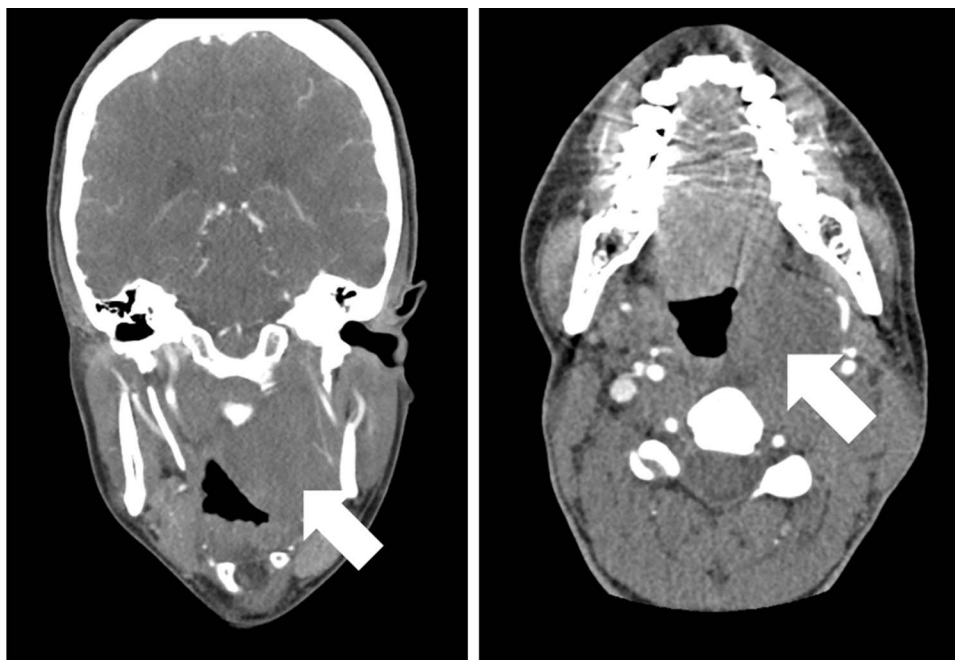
Contrast-enhanced CT angiography showed lateralization of the carotid artery and indentation of the internal jugular vein but ruled out infiltrative tumor growth and bone erosion. Left: coronar view. Right: axial view. The arrows point to the tumor.
